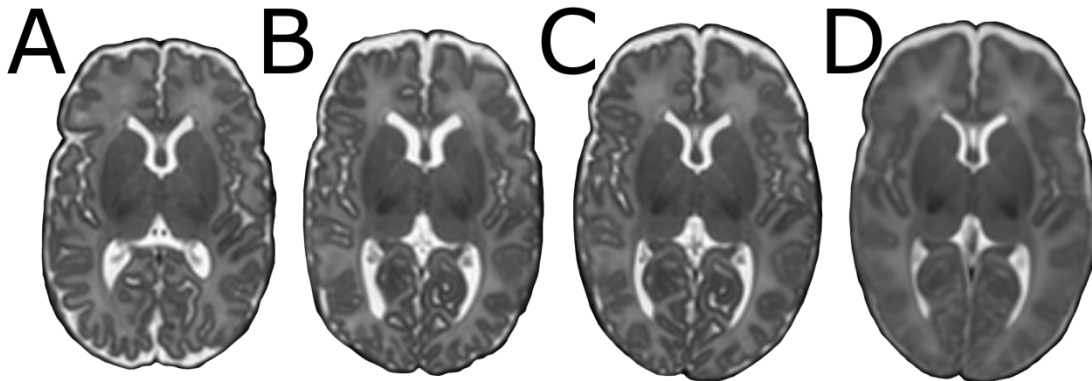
Image registration between a source and target image. A source image (A) is aligned to a target (D) with affine (B) and nonlinear transformations (C). The source image is a T_2 -weighted MRI from a preterm infant at term-equivalent age, the target is a population-average atlas as described in Kuklisova-Murgasova et al. (2011).
